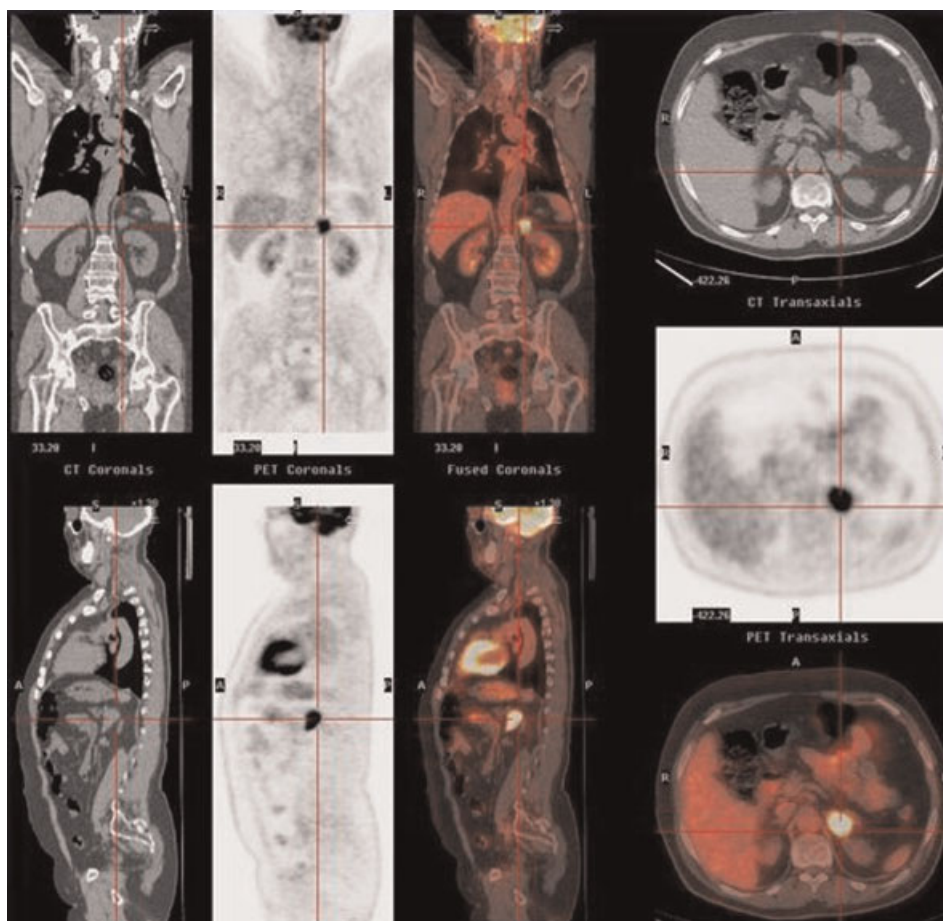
PET-CT. Patient with nonsmall cell lung carcinoma remitted for re-staging: a hypermetabolic nodule corresponding to an adrenal metastasis is demonstrated.
